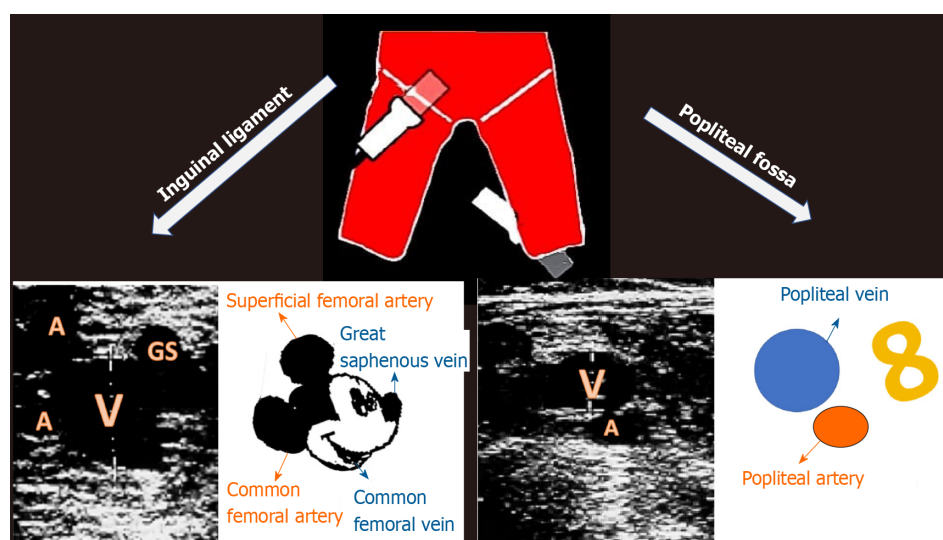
Reference points and respective sonogram images. A: Artery; GS: Great saphenous vein; V: vein.
